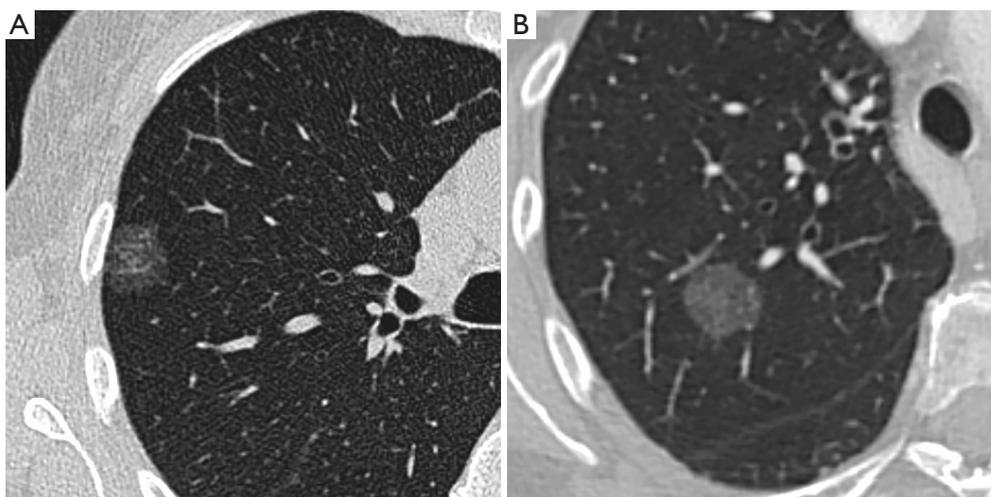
Imaging features overlap between different grades of lung adenocarcinomas presenting as pure ground-glass nodules. Chest CT scans displayed with lung window show respectively: (A) a pGGN of 20 mm in a 70-year-old female confirmed as an adenocarcinoma in situ; (B) a pGGN of 21 mm in a 66-year-old female patient confirmed on pathology as an invasive adenocarcinoma. pGGNs, pure ground-glass nodules.
